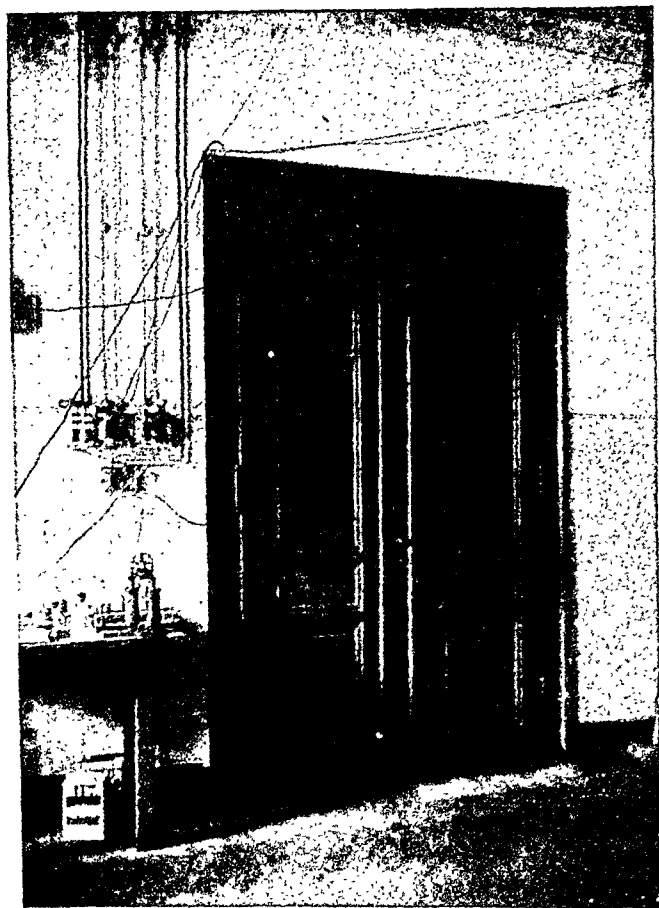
Door through which Röntgen passed x-rays. It is said that Röntgen dismantled this door to determine why plates taken through it showed certain bands of decreased density. He demonstrated that these bands were shadows cast by white lead that had been used as a filler between panels and mouldings.
